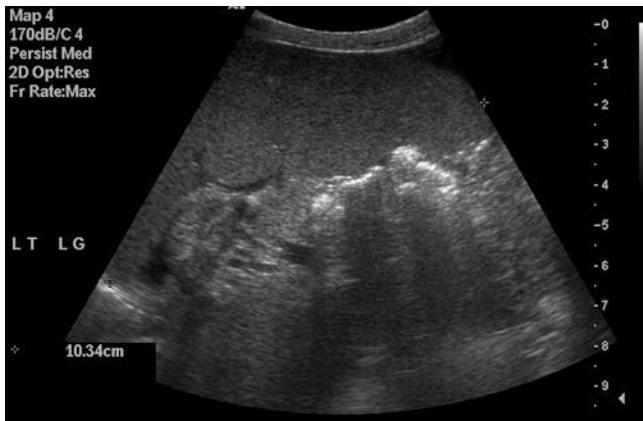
Ultrasound coronal section of the left side of the abdomen reveals splenomegaly
